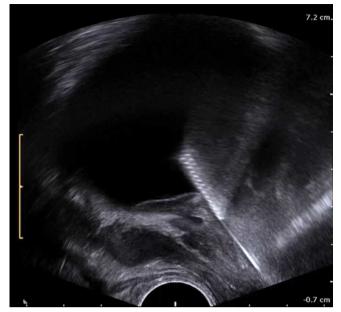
A sagittal image of the prostate and urinary bladder. The laser resectoscope tip can be noticed in the urinary bladder. The typical stripes on the resectoscope tip in ultrasonography represent the perforated coat of the tool. The examination was performed with a transrectal end-fire probe with the frequency of 12 MHz (ProFocus Ultraview, BK Medical, Denmark)
